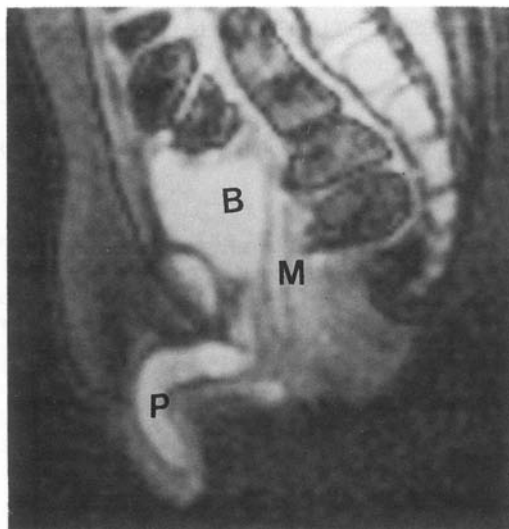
MRI abdomen of patient 7. P – penis, B – bladder, M – Mullerian cyst that was removed at laparotomy.
